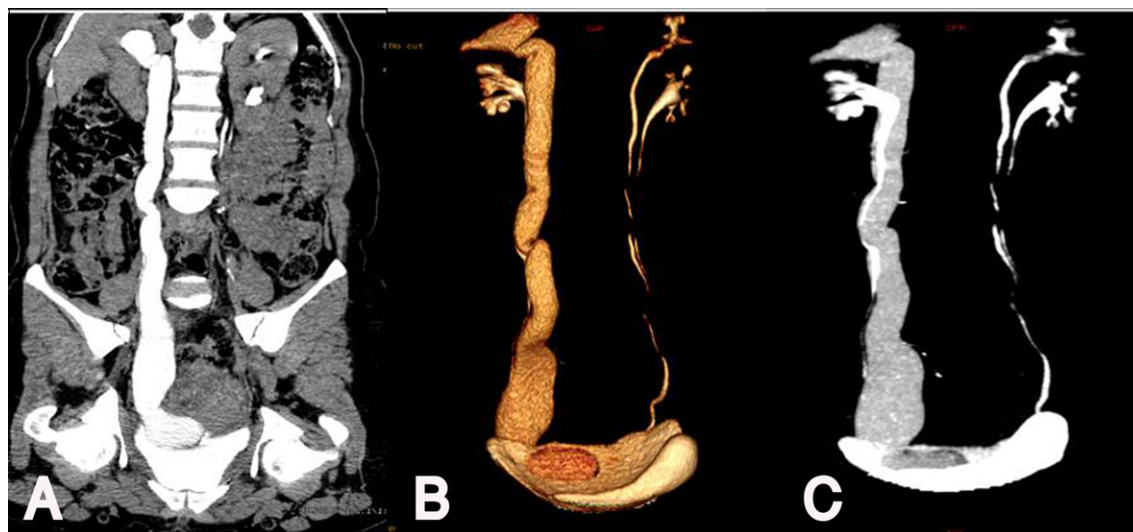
Thirty-seven year old female with right loin pain. Coronal CPR image (A), reconstructed coronal VR (B) and its corresponding MIP(C) images in the excretory phase of CT urography show clearly the cause and level of obstruction. Dilated upper moiety ureter and its distal intramural dilatation (ureterocele) giving the characteristic (Cobra head) appearance.
